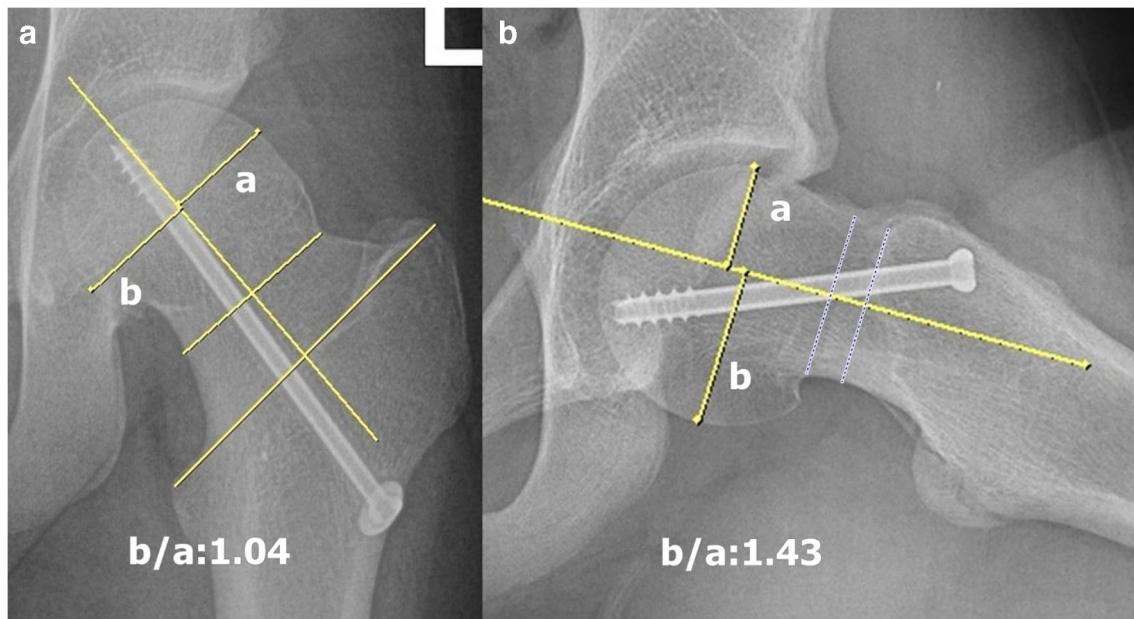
a Anterior–posterior and b lateral radiographics of the hip demonstrating measurement of the femoral head ratio
